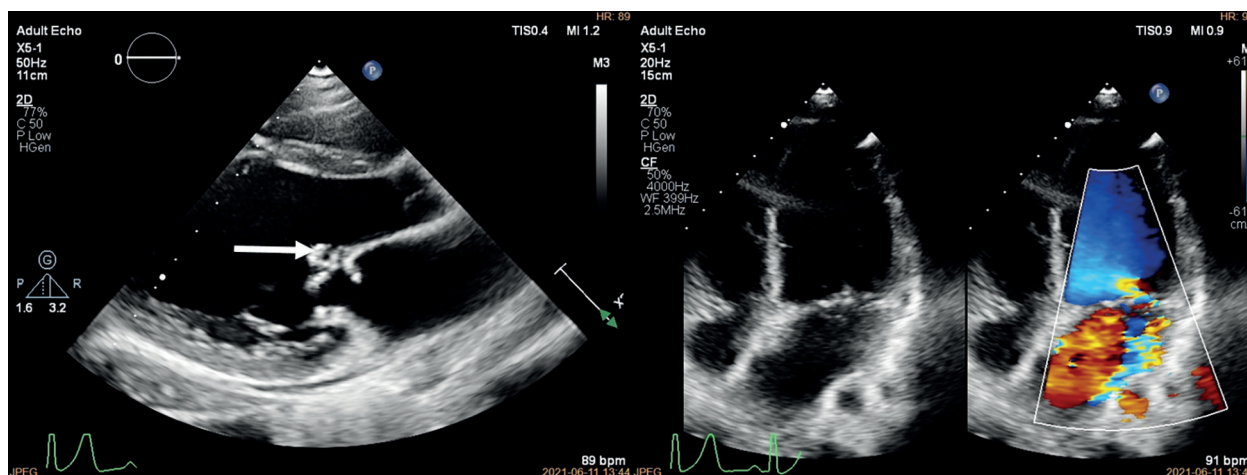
Echocardiographic image, left ventricular long axis. Left: on the anterior mitral valve leaflet vegetations that distort the valve (arrow). Right: massive valve regurgitation
